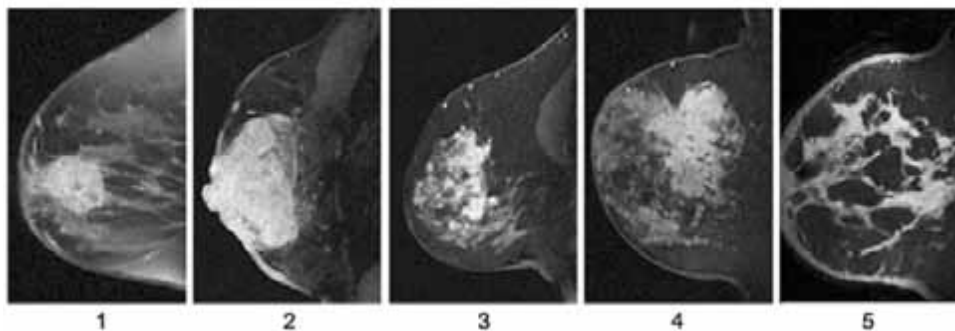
Examples of each of the five MRI phenotypes: 1 well defined, unicentric mass; 2 well defined, multilobulated mass; 3 area enhancement with nodularity; 4 area enhancement without nodularity; 5 septal spreading
